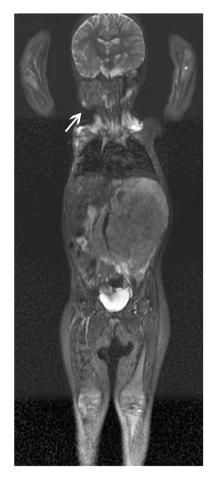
Coronal STIR MRI of a neuroblastoma patient determining metastasis suspect area on right neck (*arrow*) to be further evaluated
